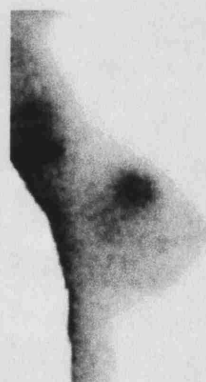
The a) x-ray mammogram and b) scintimammogram of a woman with an infiltrating ductal carcinoma. In this case the lesion was seen in the scintimammogram but not in the x-ray mammogram.
